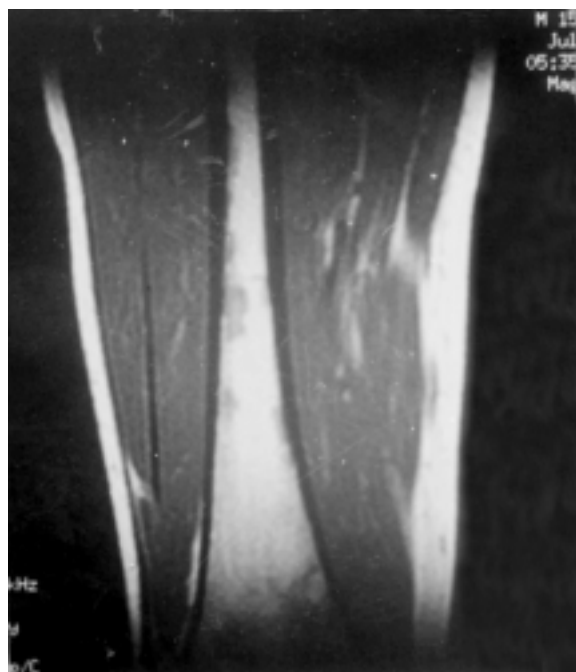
Coronal T1-weighted SE MR image show uniform replacement of the bone marrow with large focal area of low signal intensity in the shaft of the femur.
